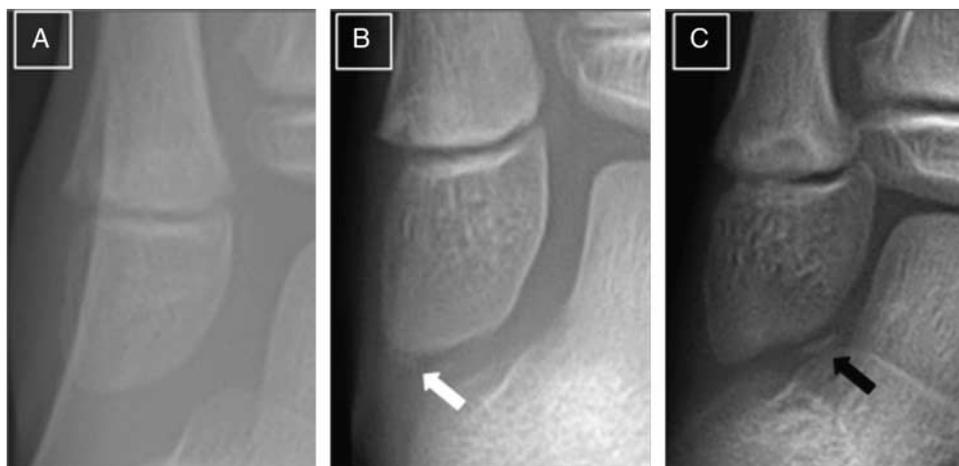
Radiographic grade of ankle inversion injury in pediatric population. Grade I, no abnormal findings in radiograph (A); grade II, irregularity or blurred epiphysis (white arrow) in radiograph (B); grade III, definite avulsion fracture (black arrow) and damage to epiphysis in radiograph (C).
